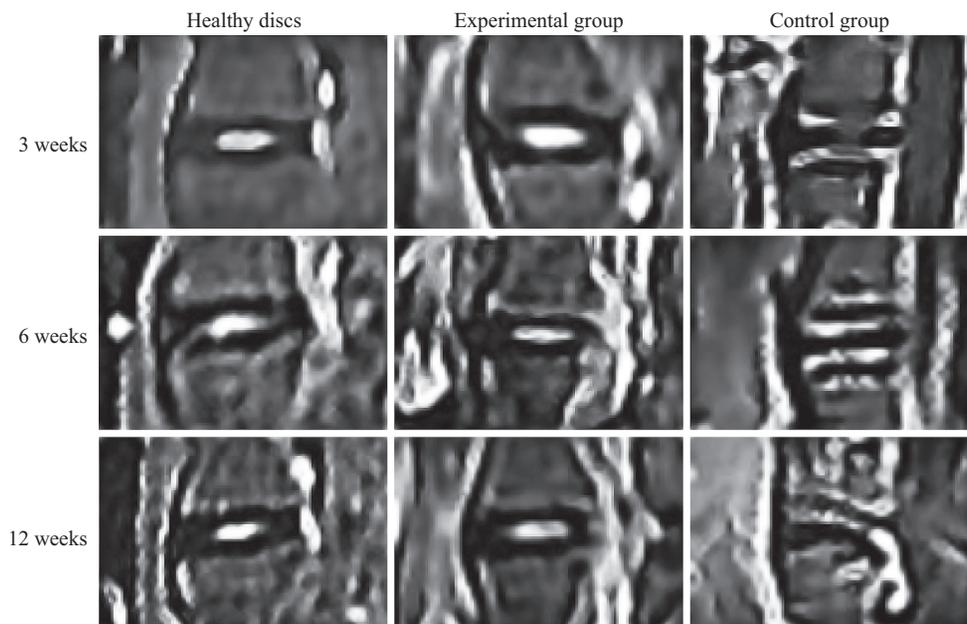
Results of lumbar MRI in T2-weighted imaging of annulus fibrosus *in vivo*
